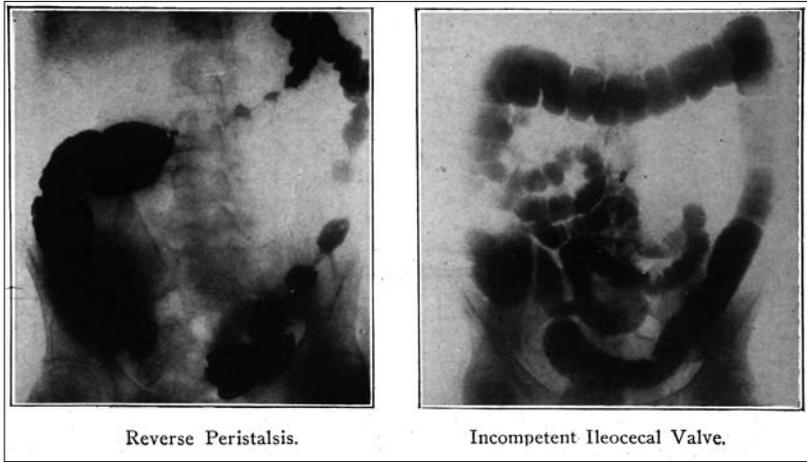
Colon X-rays, in John Harvey Kellogg, *Itinerary of a Breakfast* (New York: Funk and Wagnalls, 1918, 1926), 125.
